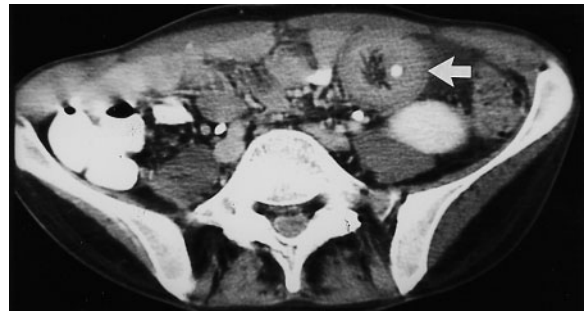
Jejunojejunal intussusception caused by a tube. A 22-year-old man with a head injury. A feeding tube was inserted via jejunostomy. Abdominal pain subsequently occurred. CT at the level of the lower abdomen shows a round, target-shaped mass in the left abdomen (arrow). The mass consists of a central hyperdense focus (the tube), a “half-moon” shaped hypodense area medial to it, the intussuscepted mesenteric fat and a soft tissue rim representing the opposing walls of the intussusciens and the intussusceptum.
